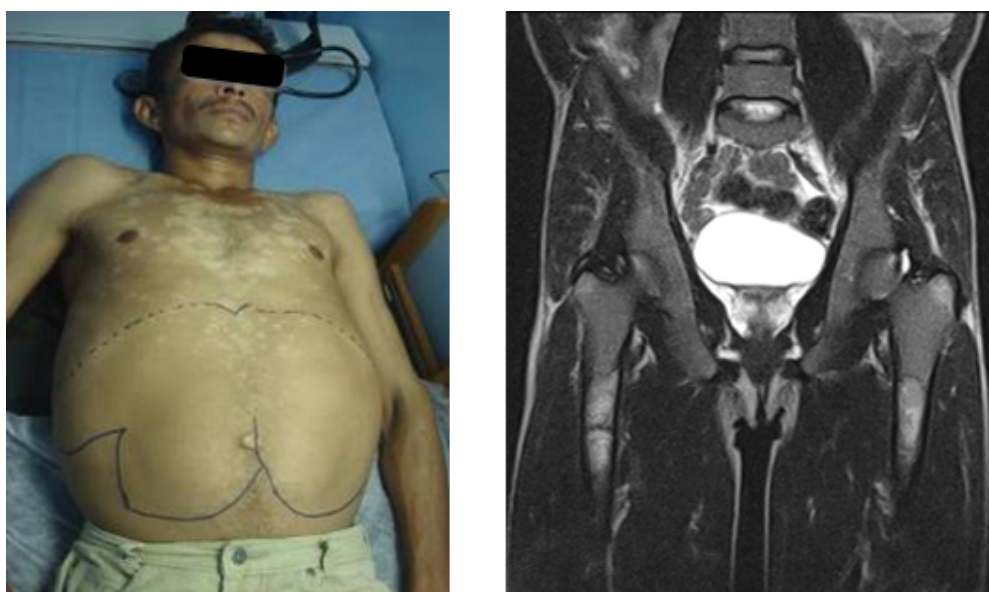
Gaucher disease patient with marked hepatosplenomegaly and skeletal involvement observed on magnetic resonance imaging of the femora.
